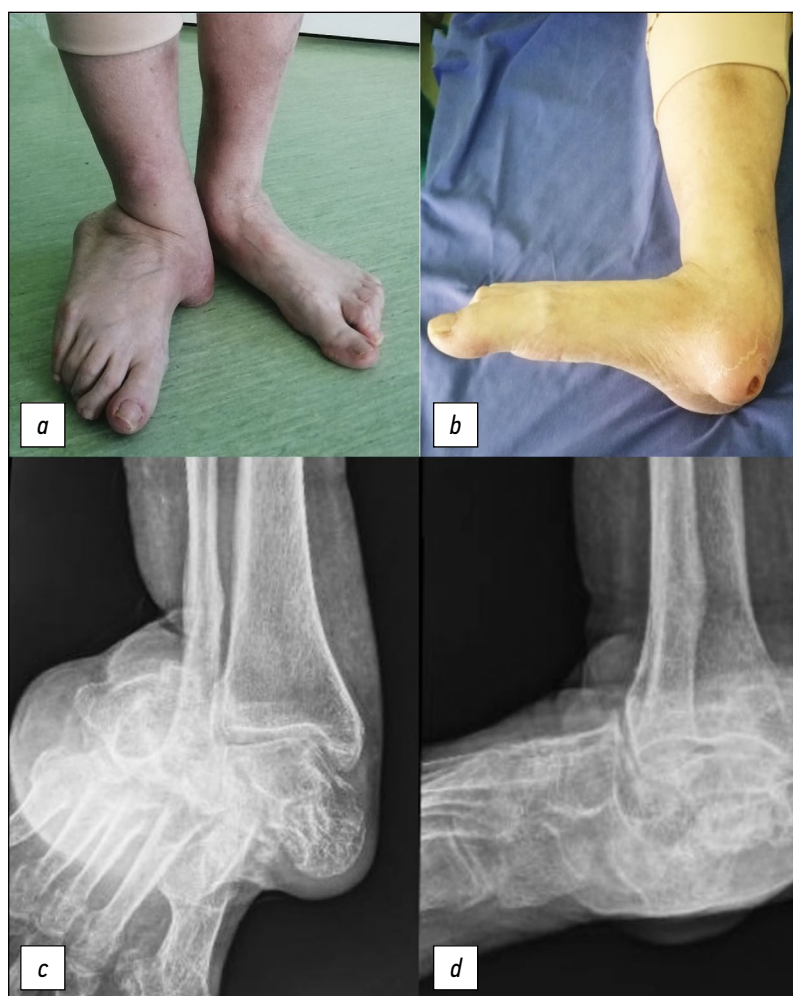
Clinical image and plain radiography at presentation: anteroposterior (*a* and *c*) and lateral (*b* and *d*) views.
